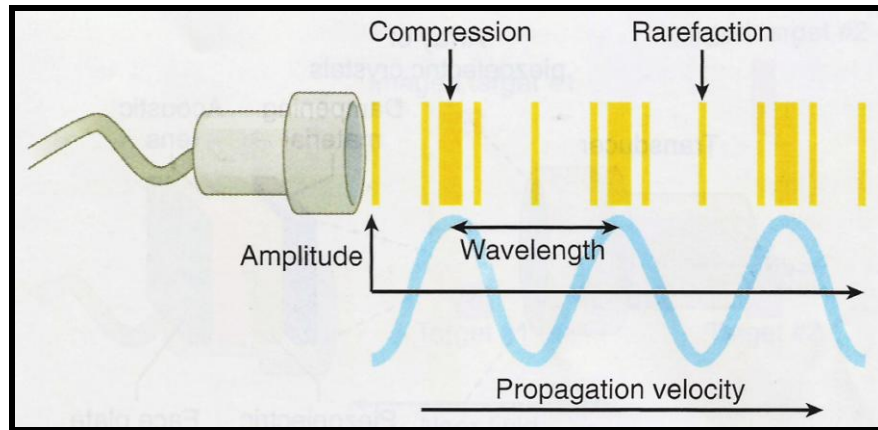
Characteristics of Ultrasound Waves
